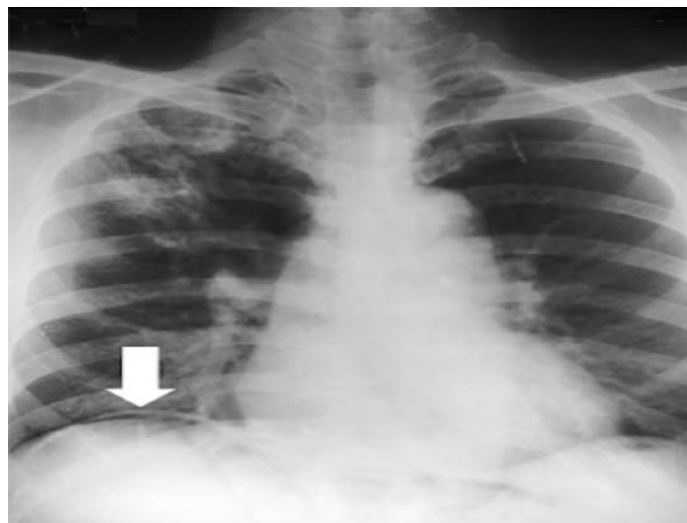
Chest radiograph with white block arrow pointing to the right hemidiaphragm and the radiolucent airstrip underneath the diaphragm.
